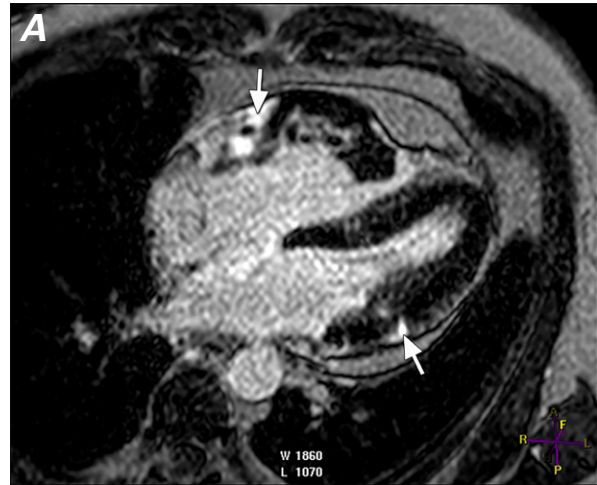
Delayed-enhancement cardiac magnetic resonance images in the A) 4-chamber and B) short-axis views, acquired approximately 15 minutes after gadolinium-chelate administration, show patchy enhancement (arrows) in both ventricles, suggesting biventricular involvement.
